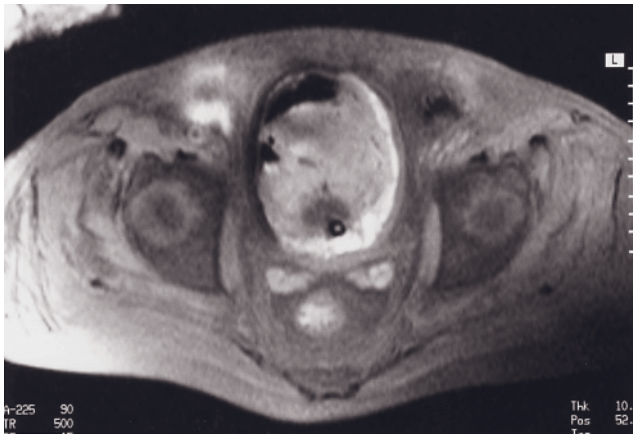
(Continued) high-resolution fast spin-echo (*h*, *i*), transverse T1-weighted postgadolinium 45-s fat-suppressed 3D-GE (*j*, *k*), and sagittal T1-weighted postgadolinium 90-s fat-suppressed 3D-GE (*l*) images in another patient with pelvic abscess and inflammation involving the bladder, prostate, and rectum. Pelvic abscess (white thick arrows, *i*, *k*, *l*) is located in the rectovesical pouch, predominantly on the right side. It is located posterior to the bladder wall, posterolateral to the prostate, and anterior to the rectum. The abscess shows high signal on T2-weighted images and prominent peripheral enhancement on postgadolinium images. Additionally, there are two areas of fluid collections in the peripheral zone of the prostate gland (black short thin arrows, *i*, *k*, *l*), one area of fluid collection in the anterior bladder wall (black long thick arrows, *j*, *l*), and one area of fluid collection posterior to the rectum (black long thin arrow, *l*). These areas also show prominent peripheral enhancement on postgadolinium images. The soft tissue adjacent to the abscess, the bladder wall, prostate, and rectal wall also shows prominent enhancement due to inflammation. Note that there is a Foley catheter and free air in the bladder lumen.
